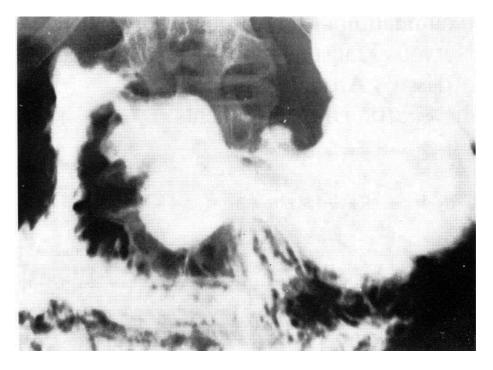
Roentgenogram of gastric ulcer localized on the lesser curvature of the stomach of a 56-year-old patient. The X-ray examination was performed by Z.Molnár M.D. at the Radiological Department, University of Medical School, Pécs, Hungary, in 1970. [Mozsik, Nagy, Tárnok , Jávor (1971): In: Pfeiffer C.J. (Ed). Peptic Ulcer. Munksgaard, Copenhagen – Lippincott, Philadelphia. pp. 323–328 (with kind permission).]
